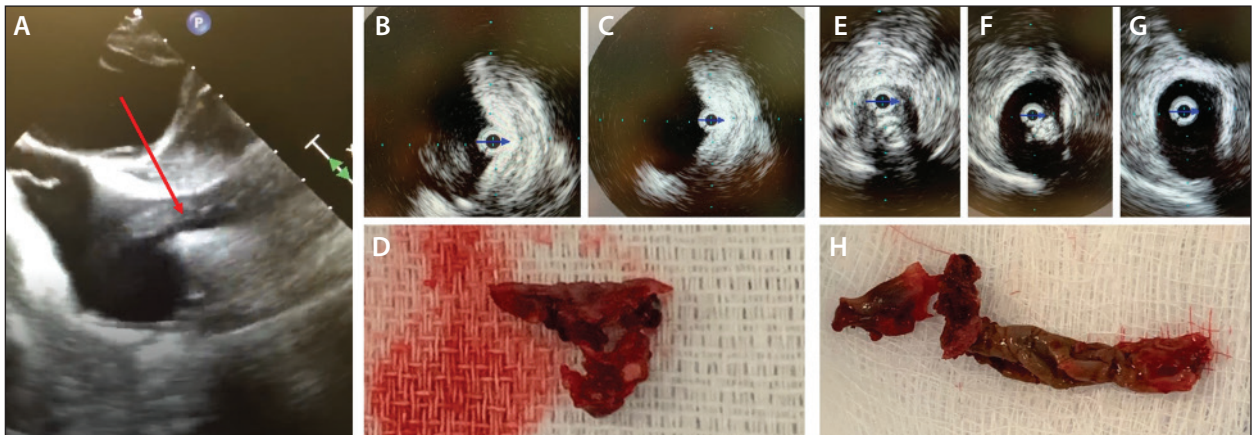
Transesophageal echocardiography showed a floating mass extending into the RA (A). IVUS of the RA confirmed the presence of thrombotic material (B). IVUS performed after FlowTriever thrombectomy showed a cleared RA (C). Aspiration with FlowTriever extracted organized material with visual signs of inflammation/infection (D). IVUS of the SVC showed persistent occlusion (E, F). IVUS performed after ClotTriever thrombectomy showed clearance of the SVC occlusion (G). ClotTriever extracted very organized thrombotic material, including remnants of the fibrin sheath (H).
